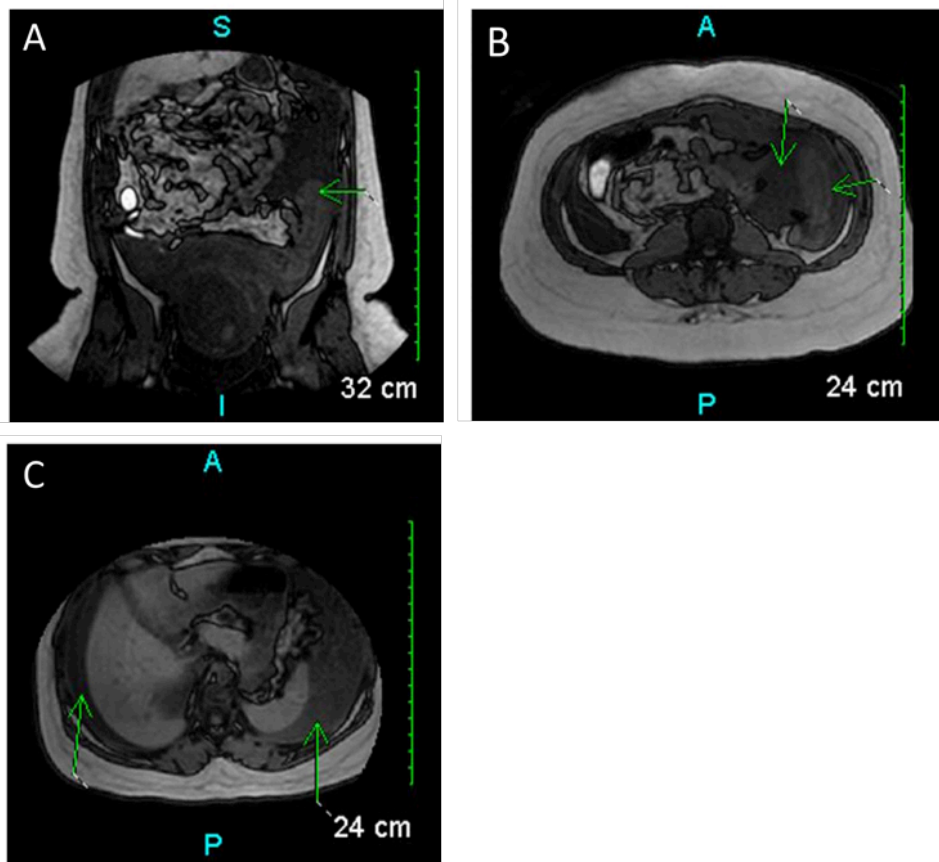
Abdominal MRI. A) Free fluid pooling in the left upper quadrant; B) Free fluid surrounding the spleen; C) Free fluid is seen collecting around the liver and tracking into the left lower quadrant.
